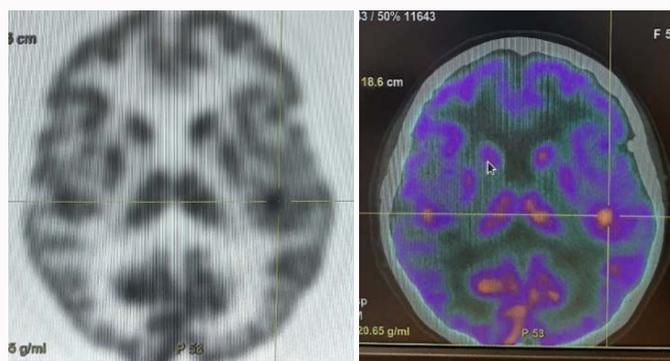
PET scan performed in February 2022, showed hyperaccumulation of the radiopharmaceutical in brain's left temporal lobe ( $SUV_{max}$  16.5).
